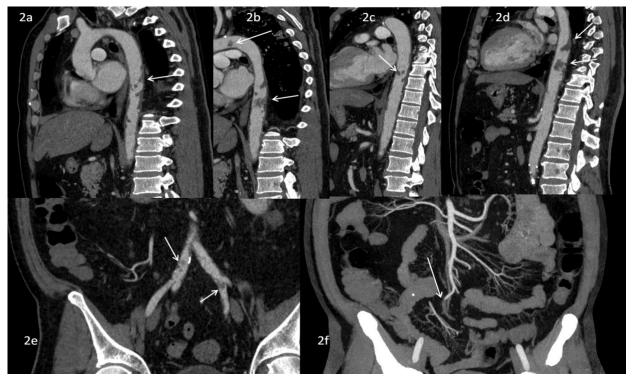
Axial and Coronal Contrast-Enhanced Computed Tomography and Angiography Images: intraluminal filling defect (arrows) in the aortic circuit (b), thoracic aorta (a-d), right common iliac artery and left internal iliac artery (e). A distal branch of the superior mesenteric artery is completely closed by the thrombus (f).
